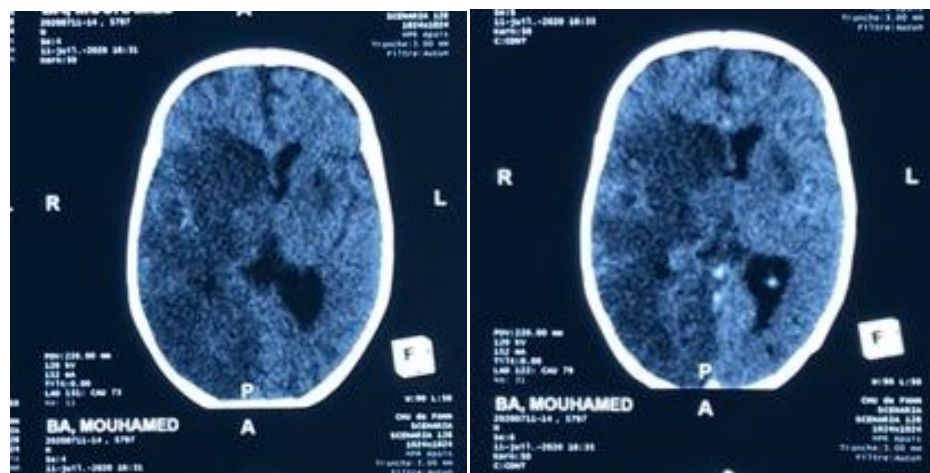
Cerebral computed tomography without and with contrast product in favour of an ischemic stroke.
